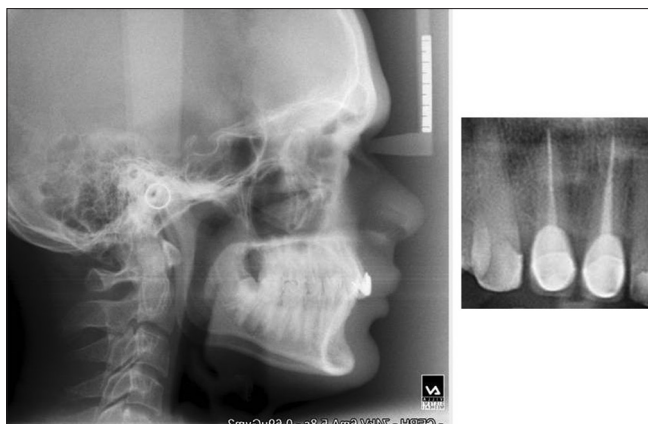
Radiographs after 10 years of follow-up
